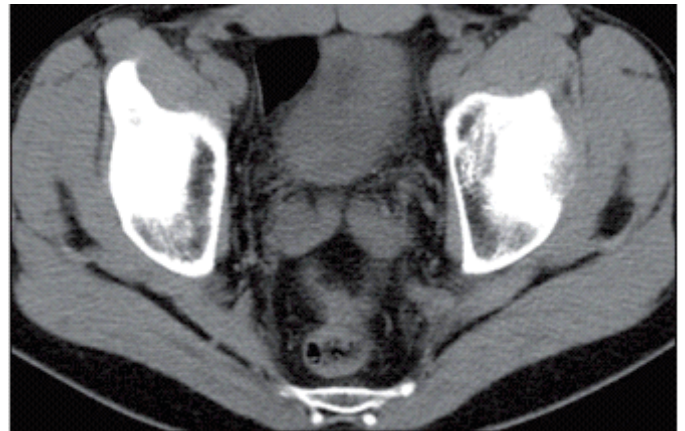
CT of a patients shows a soft tissue defect
